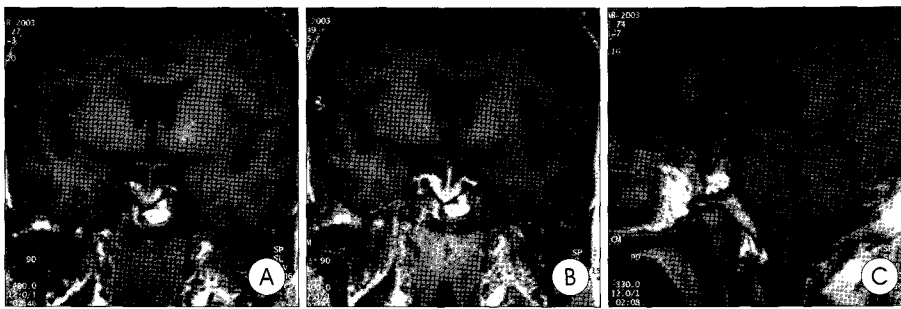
Postoperative T1-weighted coronal magnetic resonance(MR) imaging (A), gadolinium-enhanced coronal MR imaging (B) and T1-weighted sagittal MR imaging (C) show fat signal in the tumor bed, which is separated from normal pituitary gland.
